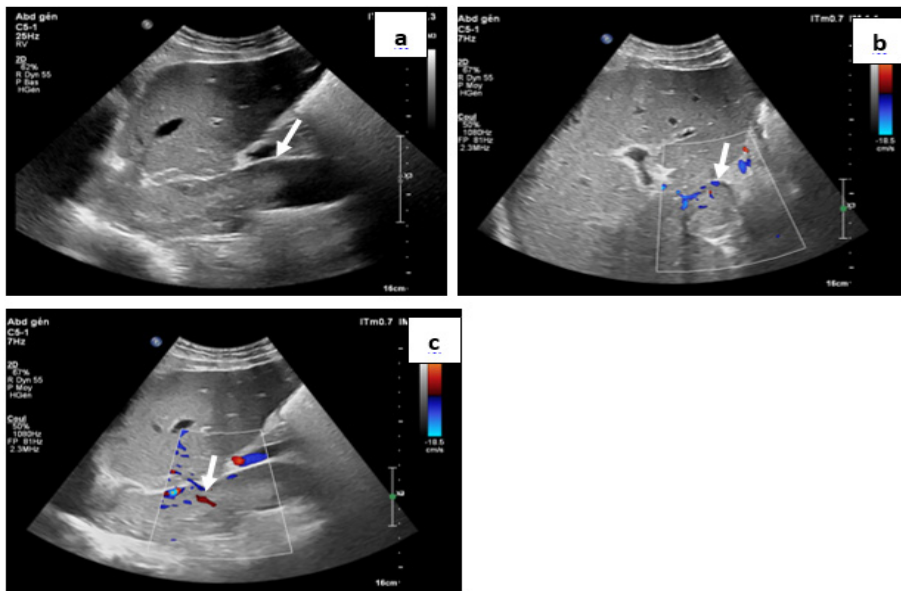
Abdominal ultrasound revealing extensive tumor thrombosis of the inferior vena cava (a) with color Doppler flow (b,c).
